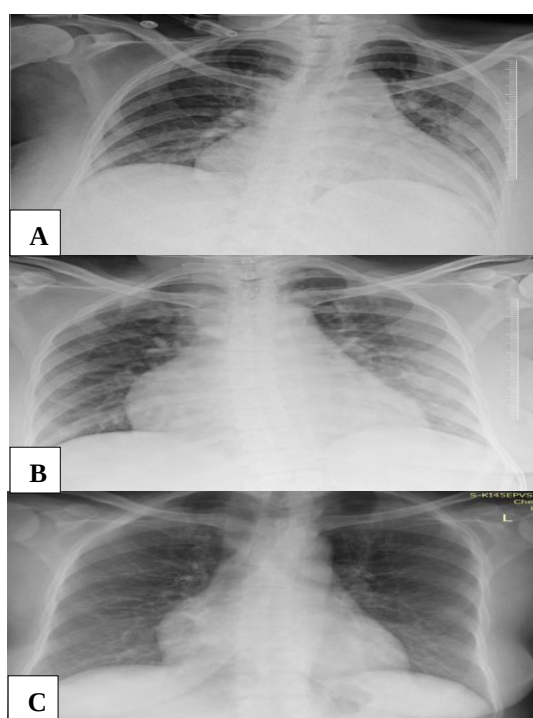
(A and B) Chest X-ray showing lung infiltrate chest X-ray; and (C) during treatment.
